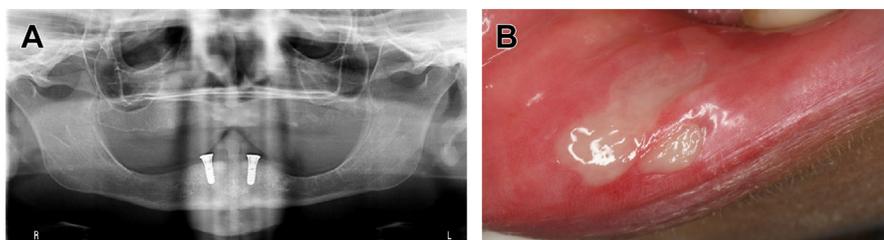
(A) Radiograph showing implant placement with no evidence of injury to the inferior alveolar nerve. (B) Clinical presentation of lip biting 1 week after the implant procedure. The patient experienced analgesia attributable to flap manipulation to locate the mental foramina during the implant placement procedure.
